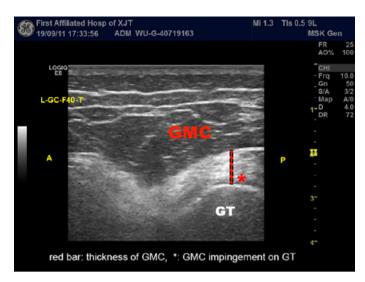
Ultrasonography transversal detection for GMC in Position II.
